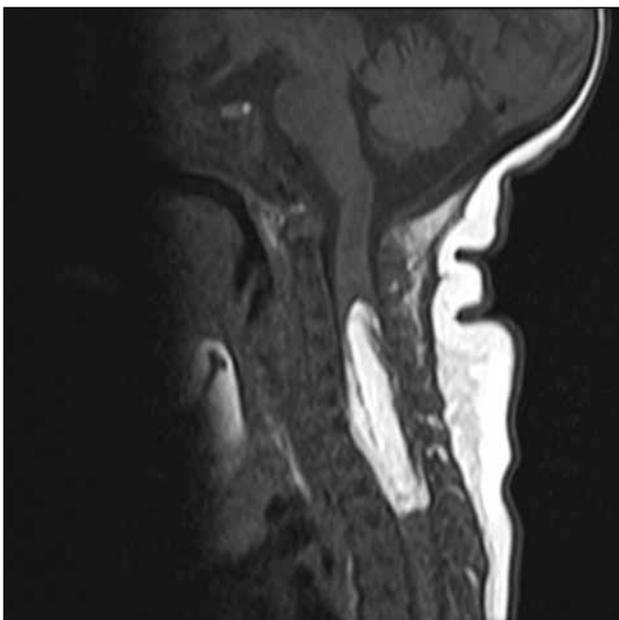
T1-weighted sagittal magnetic resonance image showing a T1-weighted hyperintense mass in the cervical spinal canal.
